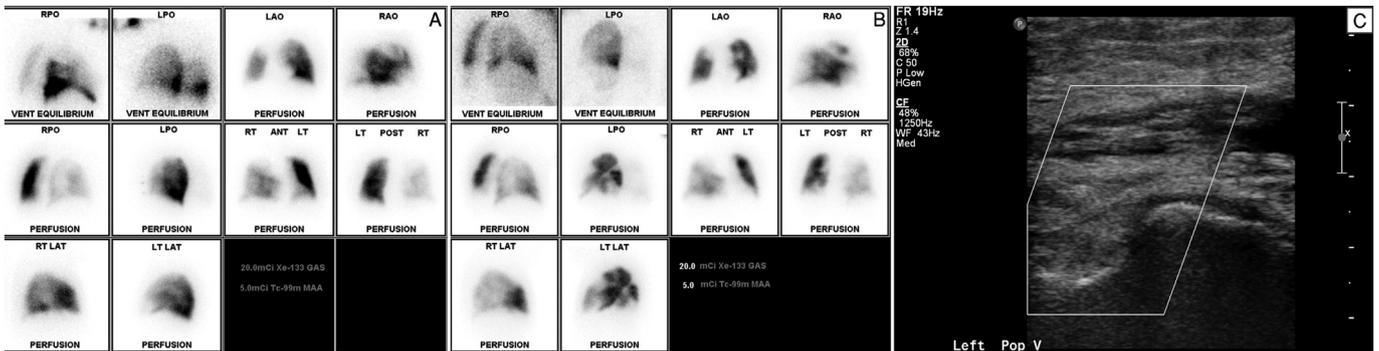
69 y/o male underwent single left lung transplant for COPD. Post transplant lung scintigraphy 11 months after transplant (A) shows heterogeneous and reduced ventilation and perfusion to the native right lung. The perfusion and ventilation to the left transplanted lung is slightly heterogeneous, with no segmental or subsegmental defects. Patient had another lung scintigraphy performed a month after the first study (B), due to shortness of breath. The study shows grossly unchanged findings in the native right lung and multiple new areas of unmatched segmental defects in the left lung, including the anterior segment of the left upper lobe, superior segment of the left lower lobe and some basal segments of the left lower lobe, consistent with a high probability scan for pulmonary embolism. A doppler ultrasound of the lower extremities (C) showed left deep venous system thrombosis.
